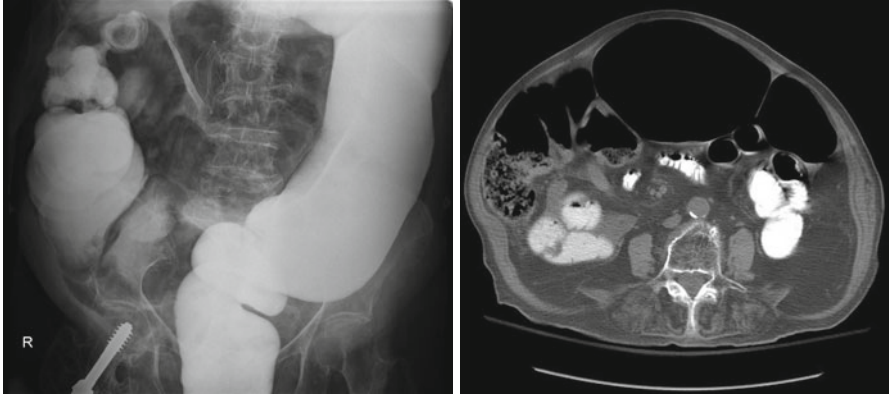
Large bowel dilatation shown on contrast enema on CT
